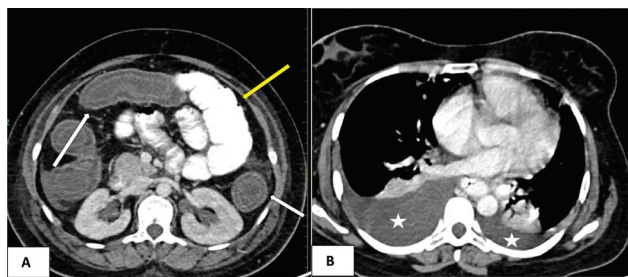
Axial sections of repeat contrast-enhanced computed tomography (CECT) of the abdomen performed on day 6 of admission after the patient worsened clinically. (A) Involvement of the large bowel (white arrows) with resolution of the proximal jejunal bowel wall thickening (yellow arrow). (B) Bilateral pleural effusion (white asterisks).
